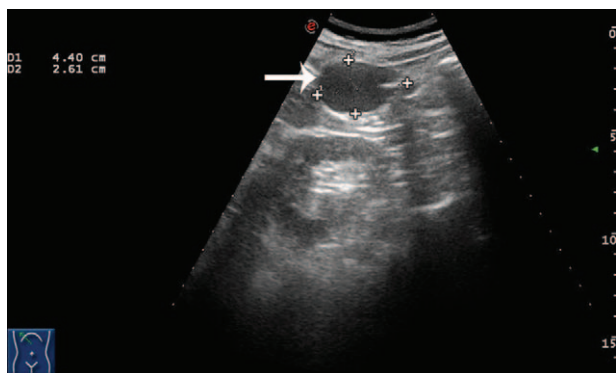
Ultrasonogram showing a 4.4 × 2.6 cm, well-defined solid mass (arrow) in the middle upper quadrant of the right abdominal cavity.
